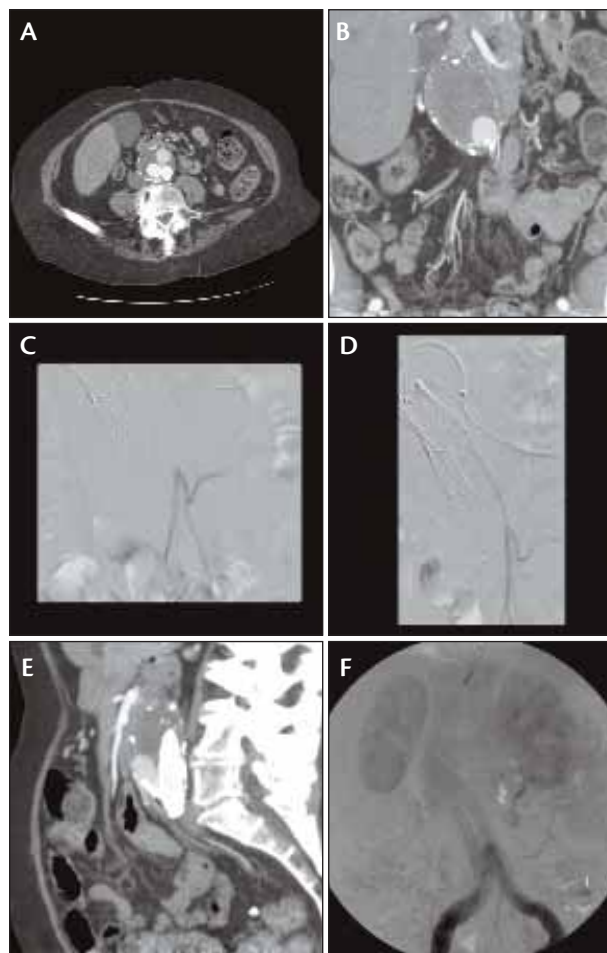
CT scan shows what was thought to be a type II endoleak (A). A coronal CT reconstruction showing the inferior mesenteric artery (IMA) contributing to the endoleak (B). Contrast in the IMA and branches. Flow is out of the aneurysm sac (C). Angiogram with a microcatheter injected well up in the aneurysm sac. Flow in the IMA branches is, again, out of the aneurysm sac rather than in, indicating that this is the exit site (D). Sagittal CT scan reconstruction with the IMA in contact with the endoleak (E). A true type I endoleak along the right iliac limb fills the endoleak and flows into the IMA branches (F).
